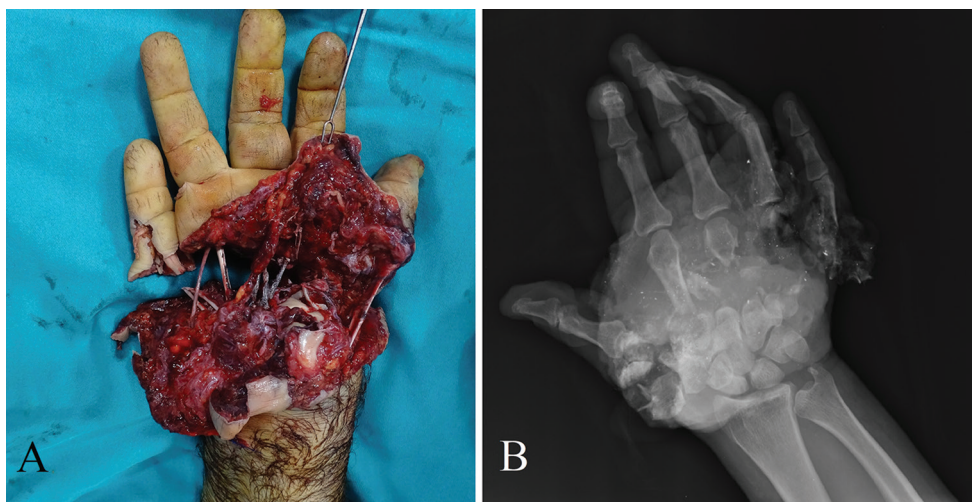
(a) preoperative view of hand injury. (b) X-ray image of hand.
